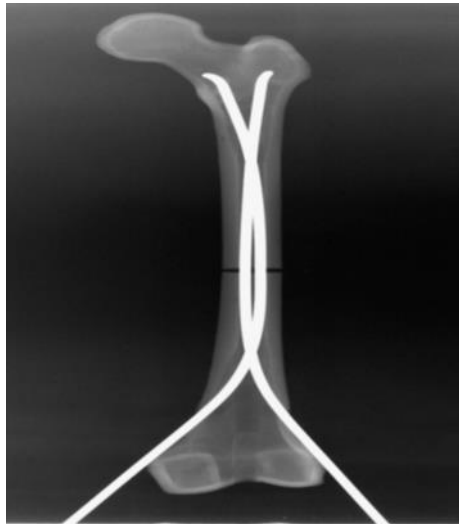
Shows radiograph of instrumented femur with nails in divergent C [10].
